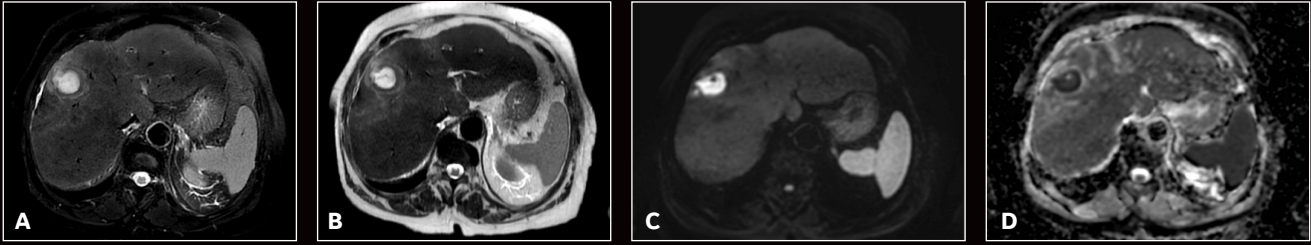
Case 1. (A) PROPELLER, (B) SSFSE, (C) DWI b=800 and (D) ADC on SIGNA™ Premier prior to the SIGNA™ Works AIR™ IQ Edition software upgrade.
